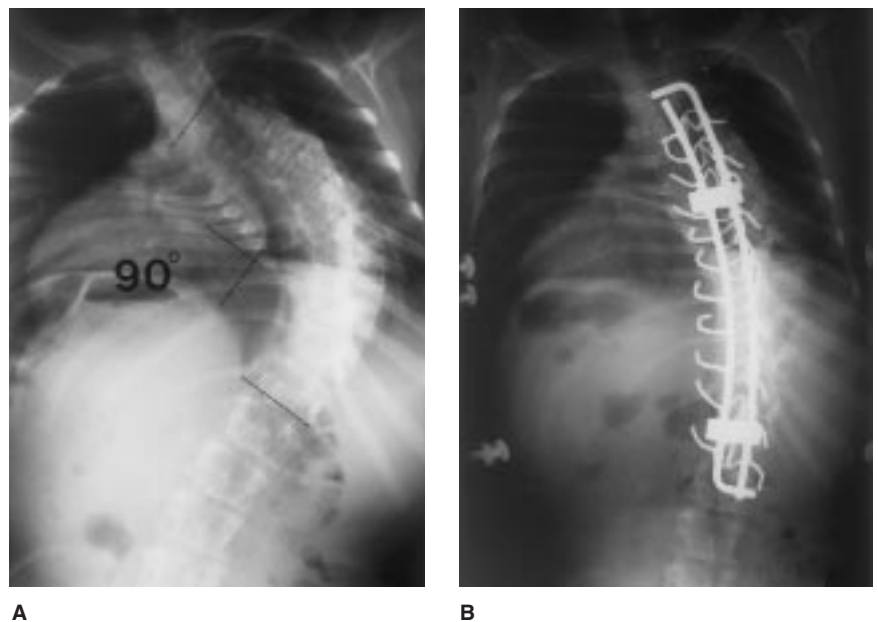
Rapidly progressive spinal deformity in a 12-year-old child with type III OI. A, Preoperative AP radiograph shows a 90-degree right thoracic curve with severe rib deformities at the curve concavity. B, AP film obtained after spinal fusion with Luque instrumentation.
